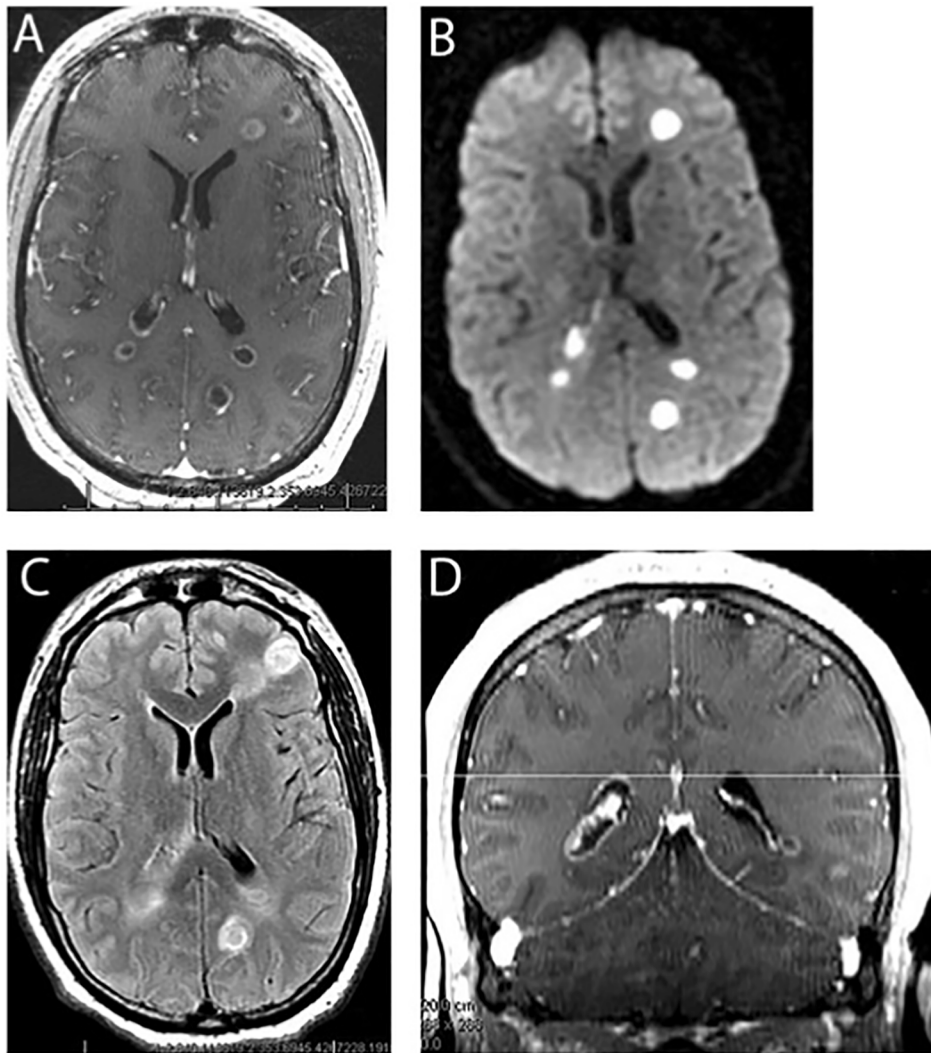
A: Axial enhanced MRI brain, B: Axial diffusion MRI brain, C: Axial FLAIR MRI brain, D: Coronal enhanced MRI brain.
